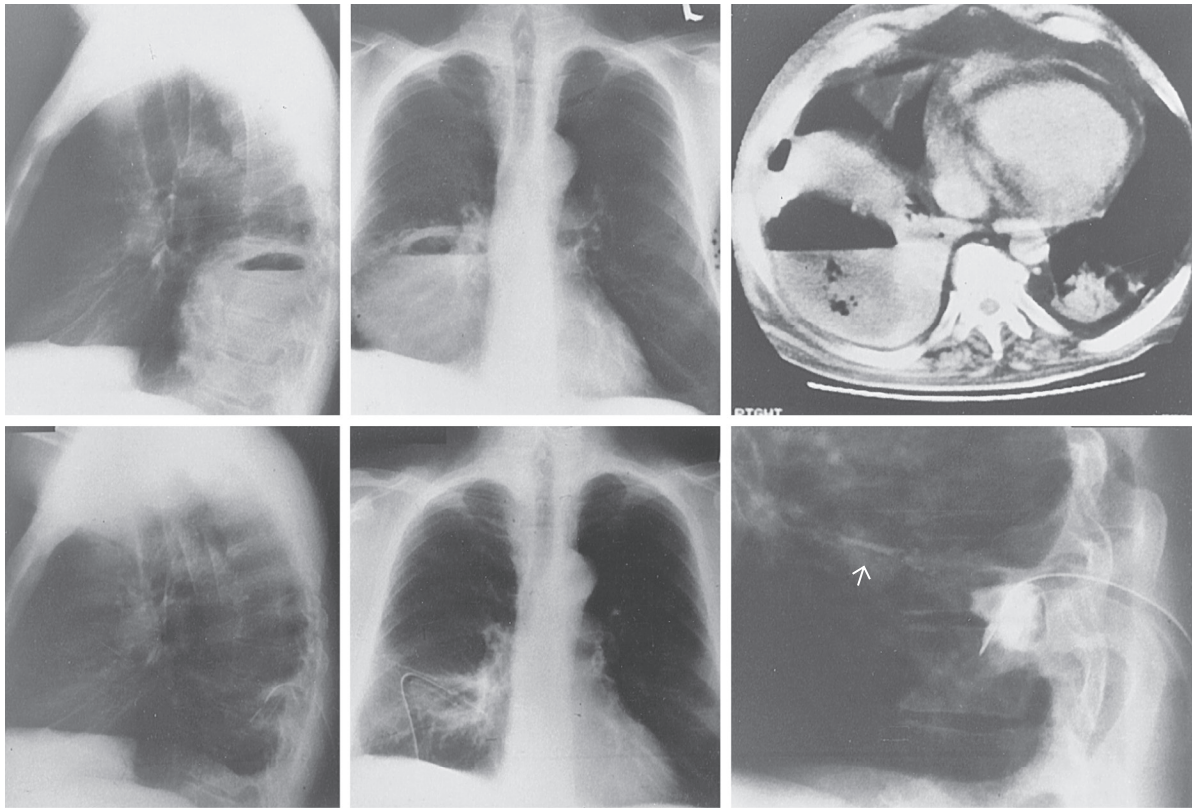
■ Computed tomography scan and chest radiographs demonstrating a large lung abscess (*upper panels*) with resolution after appropriate percutaneous drainage (*lower panels*). The arrow depicts the collapsed, contracted abscess cavity.
